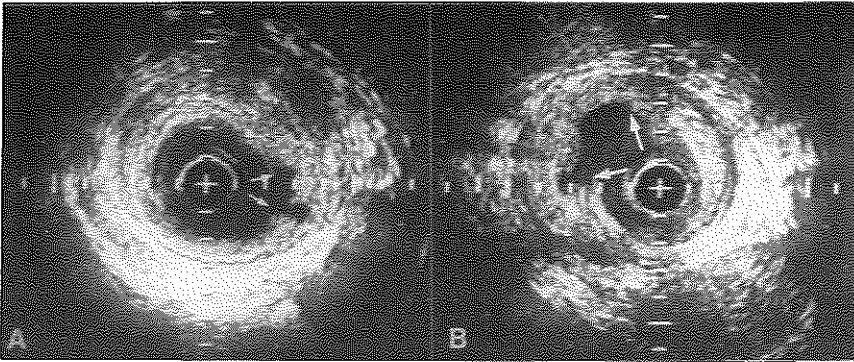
Intravascular ultrasound cross sections showing plaque rupture (arrows) after balloon angioplasty as observed in one patient. Panel A: Medial thinning is evident between 5 and 9 o'clock. Panel B: An additional dissection was present between 12 and 4 o'clock (black arrow). Calibration=1 mm. (Reprinted with permission of the Journal of Clinical Ultrasound 1991;19:294-297).
